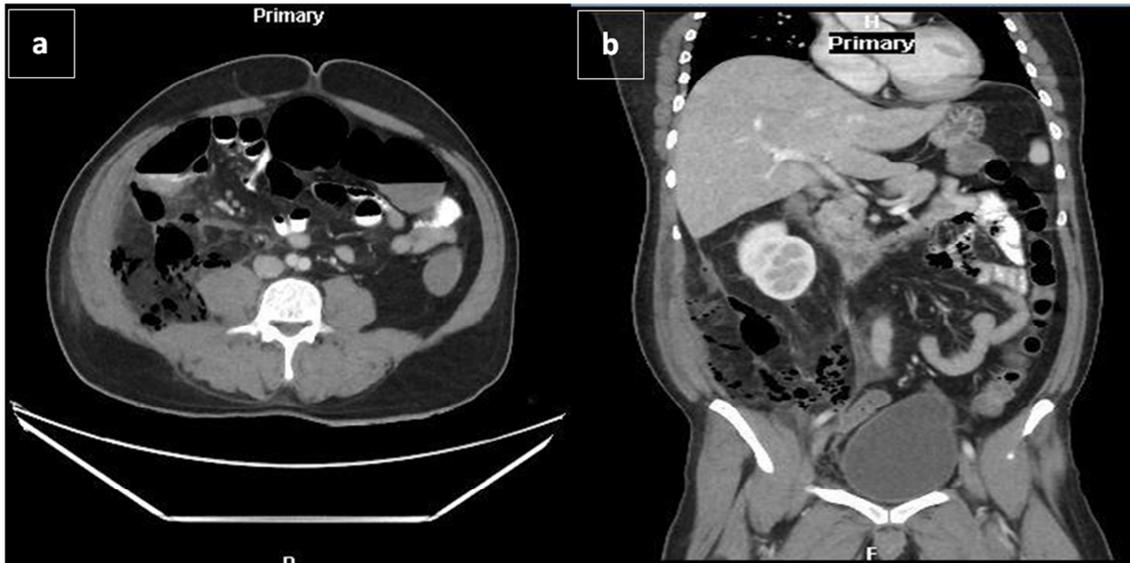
Abdominopelvic Computed Tomography (CT) with contrast on day of admission, (a) axial and (b) transverse plane, showing perforated complicated acute appendicitis with multiple free air bubbles in the right iliac fossa and right retroperitoneal region associated with smudging of the surrounding fat with multiple stranding as well as multiple small right iliac fossa and inguinal region lymph nodes.
